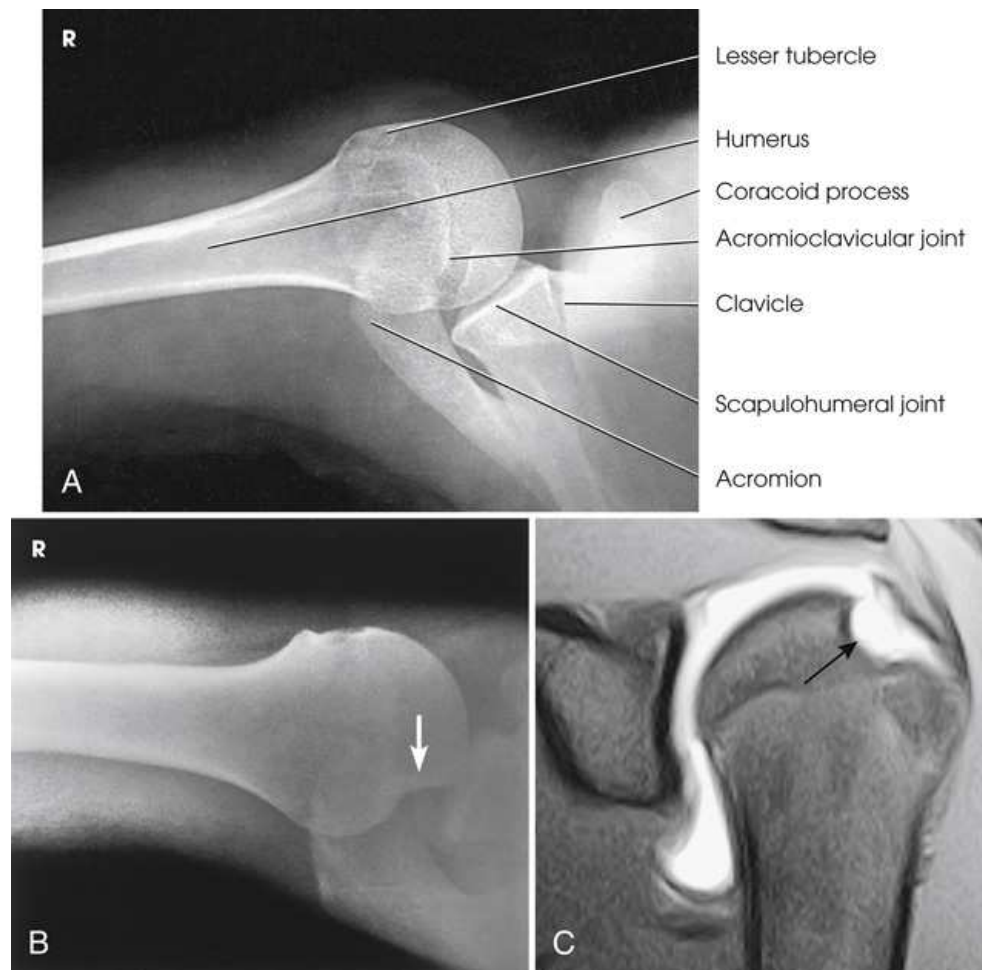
(A) Inferosuperior axial shoulder joint: Lawrence method. (B) Inferosuperior axial shoulder joint: Rafert modification showing Hill-Sachs defect (*arrow*). (C) Coronal MRI of shoulder joint showing Hill-Sachs defect (*arrow*) after recurrent shoulder dislocation. A and B, From Rafert JA, Long BW, Hernandez EM, Kreipke DL. Axillary shoulder with exaggerated rotation: the Hill-Sachs defect. *Radiol Technol.* 1990;62:18. C, From Jackson SA, Thomas RM. *Cross-imaging made easy*, New York: Churchill Livingstone; 2004.
